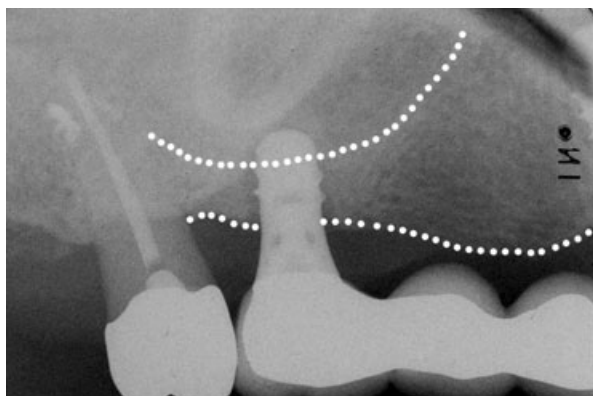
Radiograph of a 6 mm implant that was inserted utilizing the osteotome technique without grafting material. The residual bone height was only 3 mm. After 6 months of functional loading, the implant became loose and had to be removed. After a healing time of 2 months, the maxillary sinus floor was elevated with the lateral approach and two new implants were placed simultaneously (the dotted lines represent the outlines of the residual bone).
